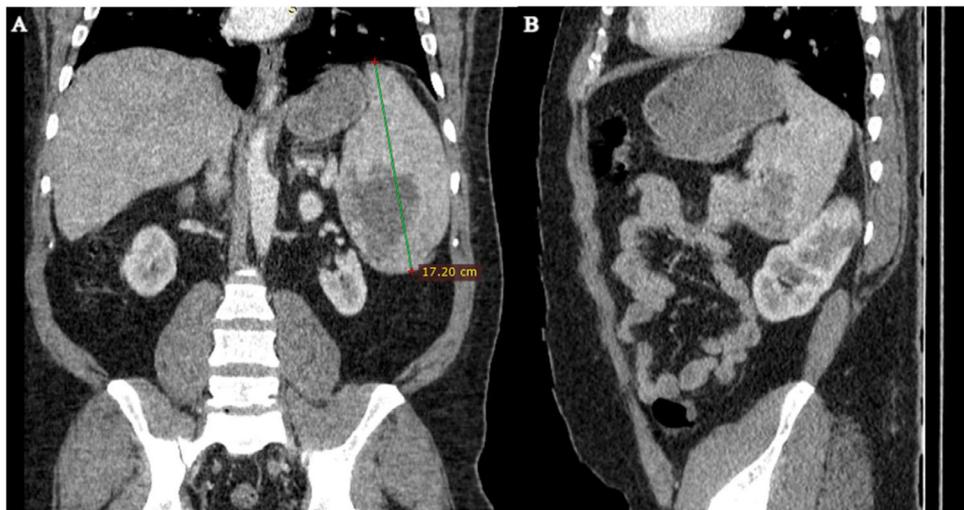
Reconstructed coronal (A) and sagittal (B) portal phase CT: The splenic lesion is causing splenomegaly, which measures 17 cm. The sagittal view depicts the relative positions of the splenic and left renal masses.
